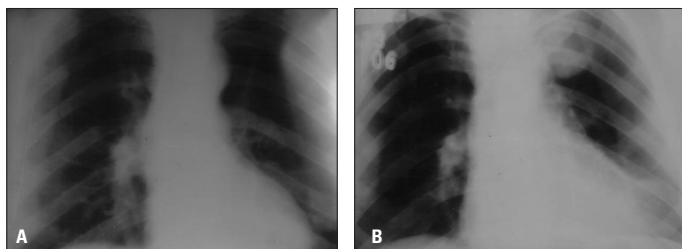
(A) A normal chest X ray imaging obtained before the coronary artery bypass surgery. (B) Postero-anterior chest roentgenogram demonstrating an intense, round, homogeneous density, 5x5cm in size, in the upper zone of the left hemithorax
